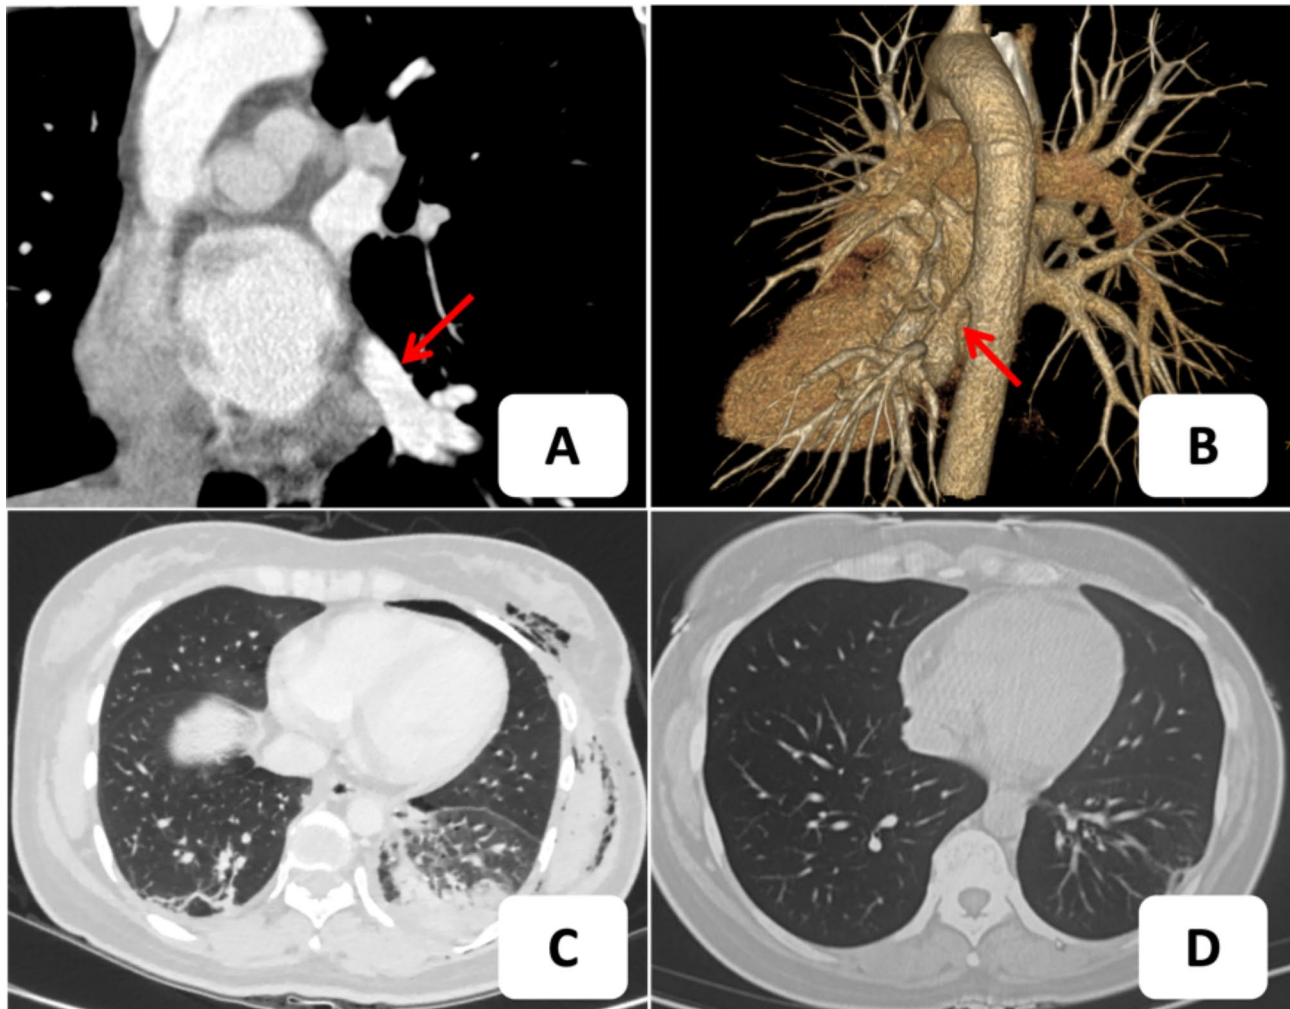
Chest Radiographic Images of Case 1 A,B: Preoperative contrast-enhanced chest CT and three-dimensional CT reconstruction, revealing an abnormal artery originating from the thoracic aorta. C,D: Postoperative follow-up imaging of Case 1. Chest CT at three months post-surgery shows exudative changes in the left lower lobe, while chest CT at eight-year post-surgery shows no structural changes in the left lower lobe, with only mild atrophy observed
